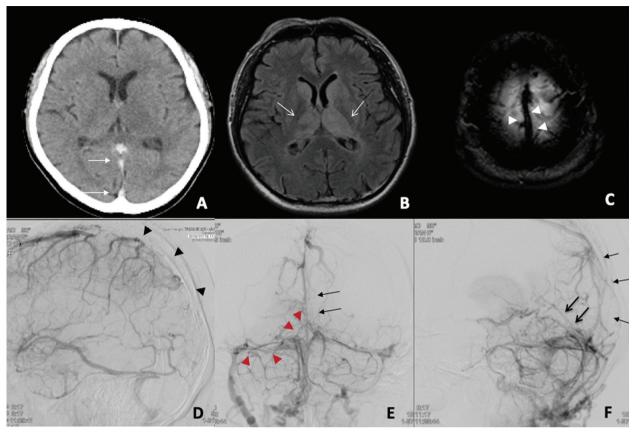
(A) Initial Plain CT reveals abnormal high density in the straight sinus (white closed arrows). (B) MRI (FLAIR) shows mild signal high intensity in bilateral thalami (white open arrows). (C) MRI (T2*-weighted imaging) reveals longitudinal low intensity signal in the SSS, suggesting intra-sinus clot (white arrowheads). (D) Right CAG (lateral view) demonstrates severe stenosis of the proximal
